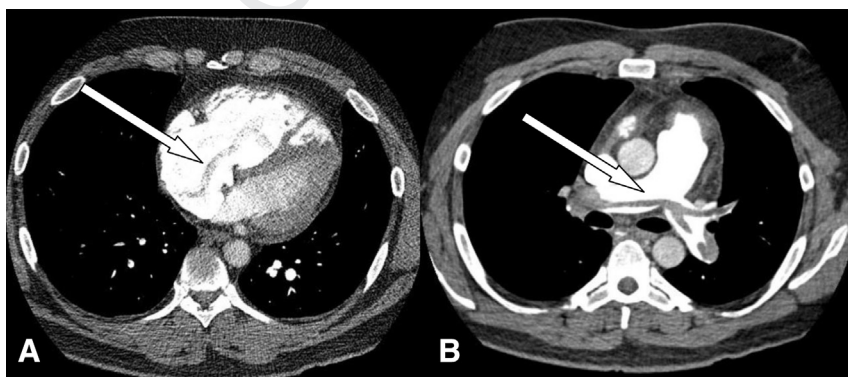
Computed tomography pulmonary angiogram demonstrating (A) serpiginous density in the right heart and (B) saddle pulmonary embolus.
